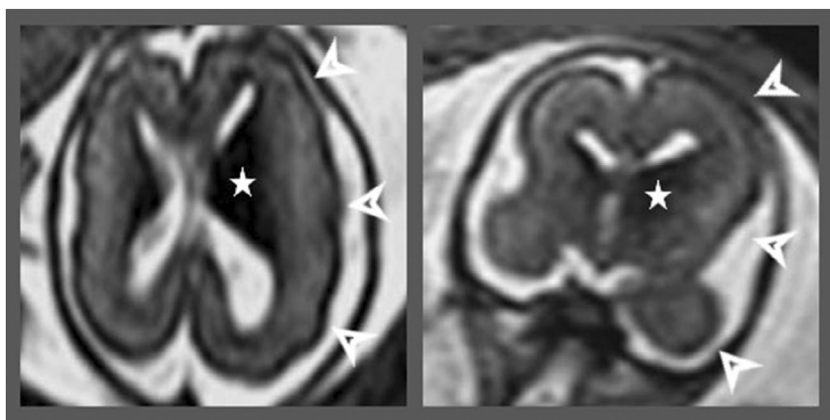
Hemimegalencephaly, 21 GW. (A) axial and (B) coronal T2-weighted images show asymmetric enlargement of the left cerebral hemisphere (arrows) and ipsilateral ganglionic eminence (stars). Case courtesy of Andrea Righini, Milan, Italy
